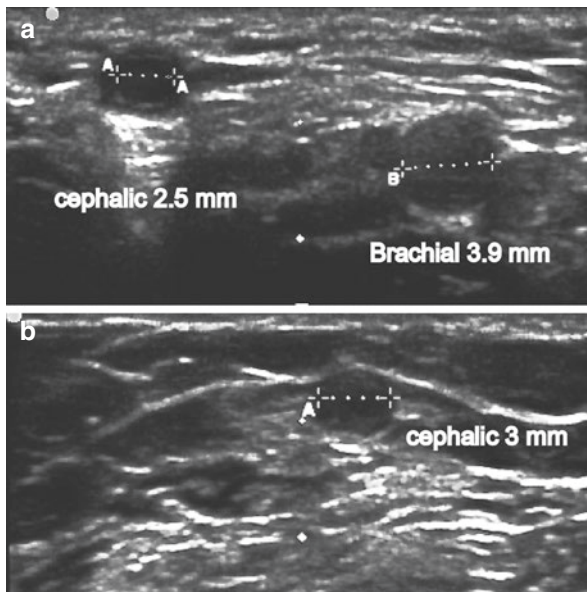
Preoperative evaluation before AVF creation. Preoperative ultrasound images reveal (a) cephalic vein (*left*) and adjacent brachial artery (*right*) at the elbow of a right arm with venous tourniquet applied; (b) upper arm cephalic vein
